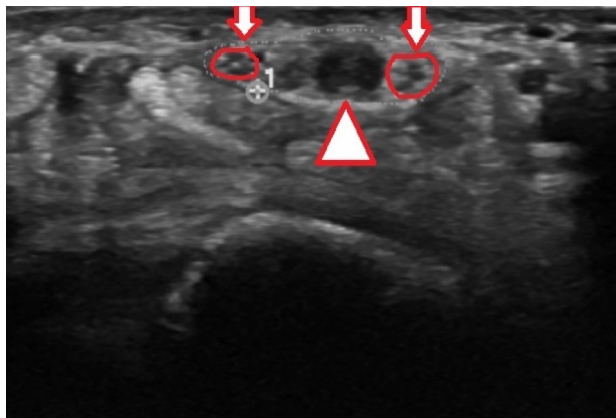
Axial section sonographic and colour Doppler image. Persistent median artery with bifurcated median nerve on its either side (arrows). The vessel was filled with echogenic thrombus (arrowhead). No flow is seen in the lumen.
